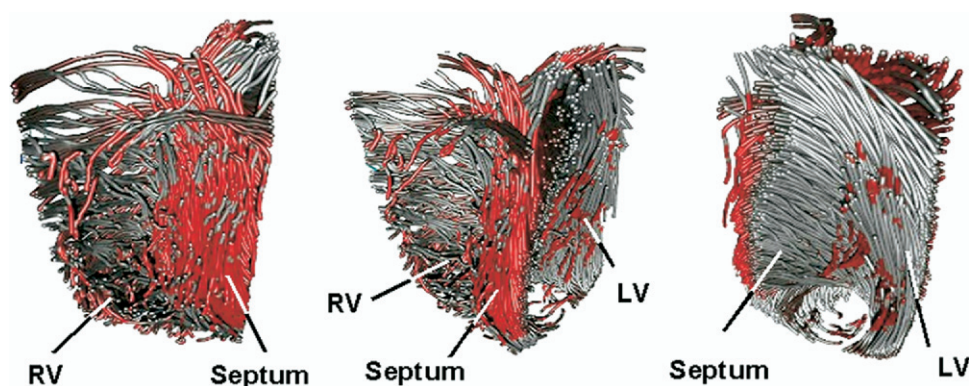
Fiber tracking performed in the LVs and RVs of the human heart using regularized tensor diffusion MRI visualization techniques. The geometry of the fibers of both RVs and LVs and the septum is shown and the continuity of the LV fibers with the septum can be seen. The transverse fiber orientation of the RV free wall is also evident. The left figure shows the RV and septum, the center figure shows the septum in a transverse view, and the right image shows the left side of septum. Note the fiber angulation mirrors the muscle fiber orientation in Figure 1. (Reprinted with permission from Lawrence National Berkeley Laboratory Publications.¹³)
